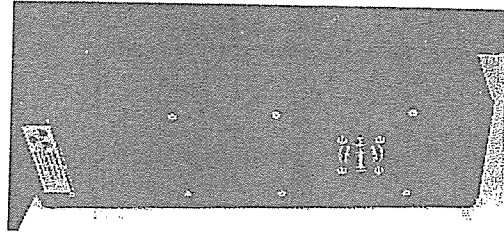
X-ray tube unit.
